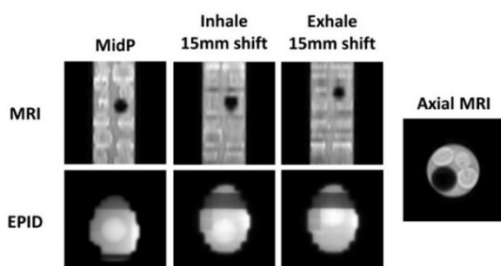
Left: Coronal MRI (target=black) and EPID image (target=white) in midP and in inhale and exhale position with baseline shift 15mm. Right: Axial MRI.
